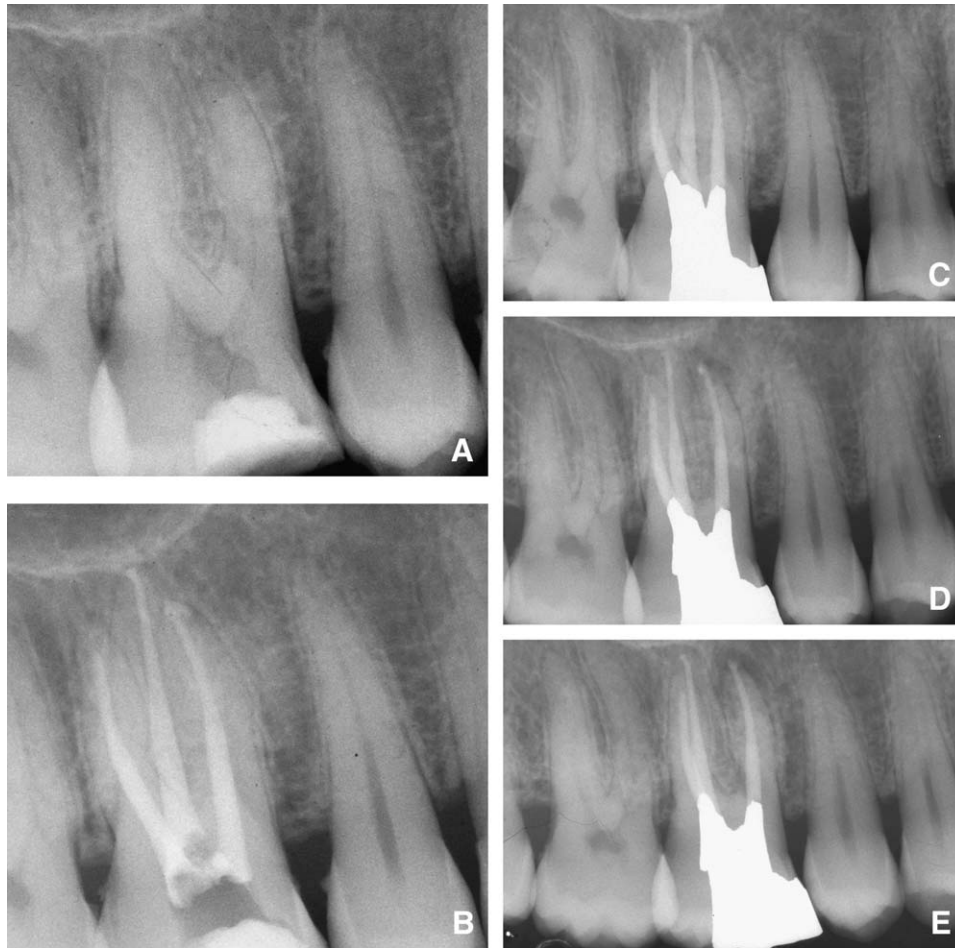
Demonstration of a case with development of postoperative periapical lesion. A, Preoperative radiograph. B, Immediate postoperative check. Note presence of a small overfilling on the mesial root. C, One-year follow-up. A small radiolucency is seen on the mesial root. D, Two-year follow-up. Presence of radiolucency of a larger dimension than in C. E, Three-year follow-up. Lesion appears manifest.
